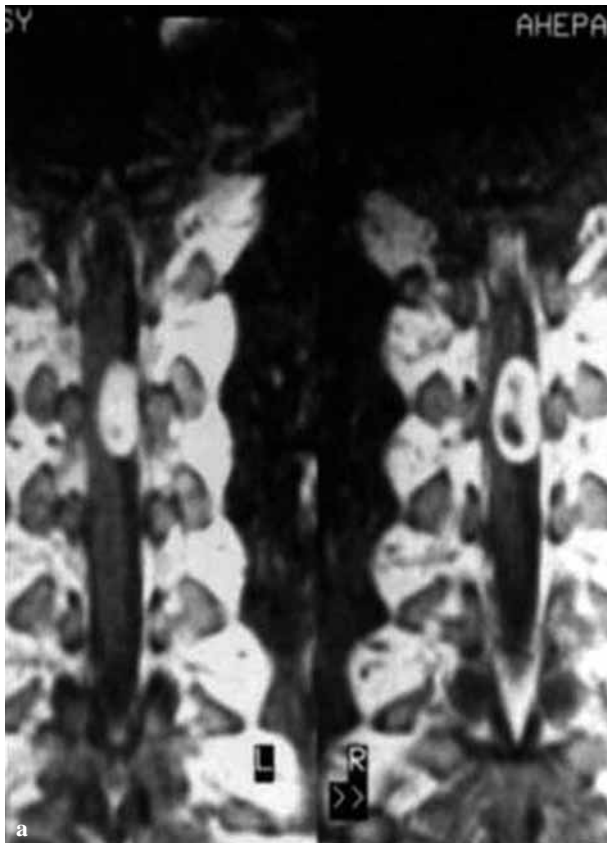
a,b. — Spinal MRI shows a well-demarcated 2,5 × 0,8 cm midline posterior, intradural, extramedullary thoracic spinal tumor at the T5-T6 level.
